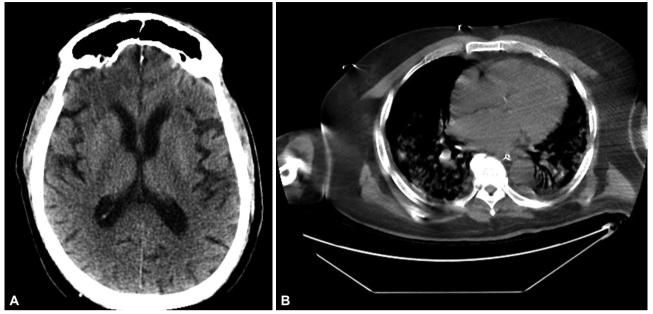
Noncontrast brain CT scan obtained on the 22nd hospital day, showing no infarct or hemorrhage within the deep gray nuclei and the thalami (A); noncontrast chest CT scan obtained on the 36th hospital day, revealing ground-glass opacities in the posterior region of the chest (B).
